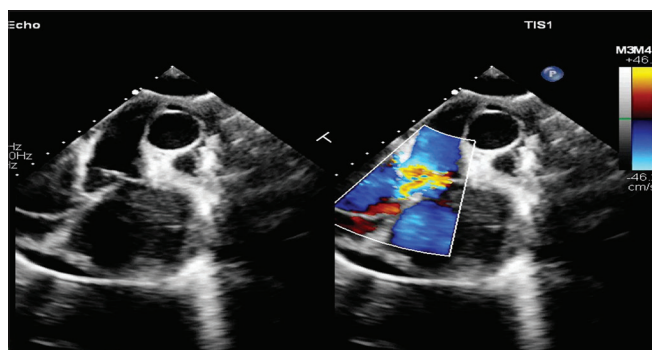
Suprasternal long-axis echocardiographic image showing sinus of Valsalva aneurysm with rupture into the right atrium.
